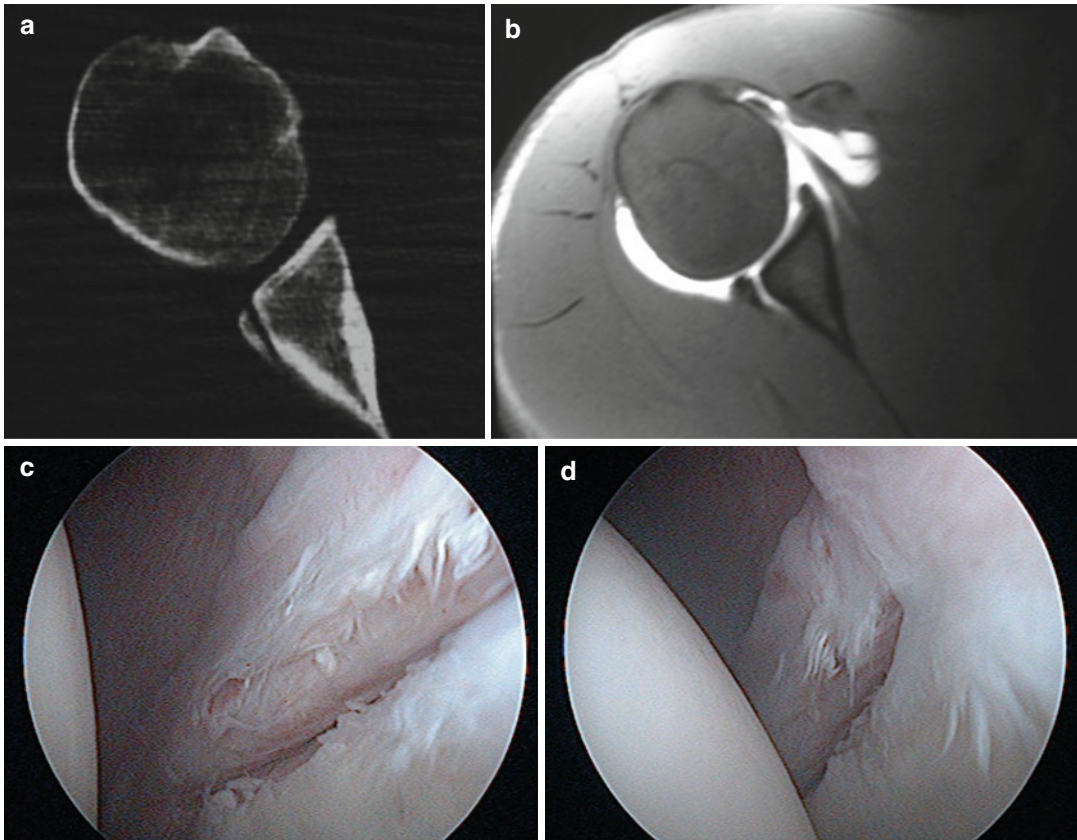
Fracture of the posteroinferior rim of the glenoid – reversed bony Bankart lesion as seen on CT scan (a), MRI arthrogram (b), and arthroscopy (c, d)
